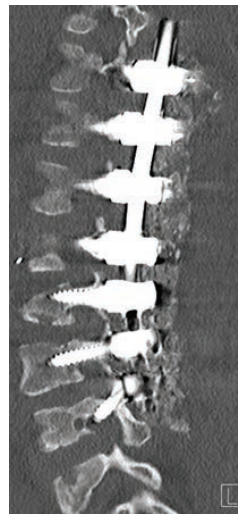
Postoperative sagittal CT demonstrating misplaced screw at L4 pedicle on the left. Screw with noted inferior and medial breach. This is notably on the contralateral side of the patient's symptoms.
